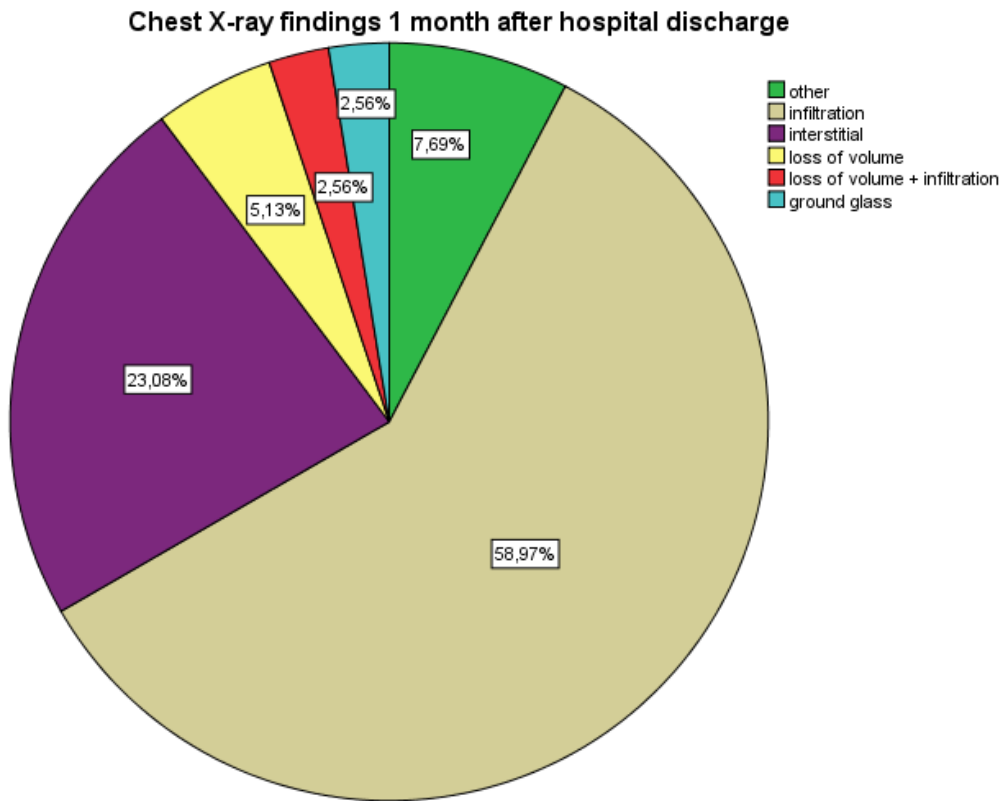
Chest X-ray findings 1 month after hospital discharge among those informed as pathological
